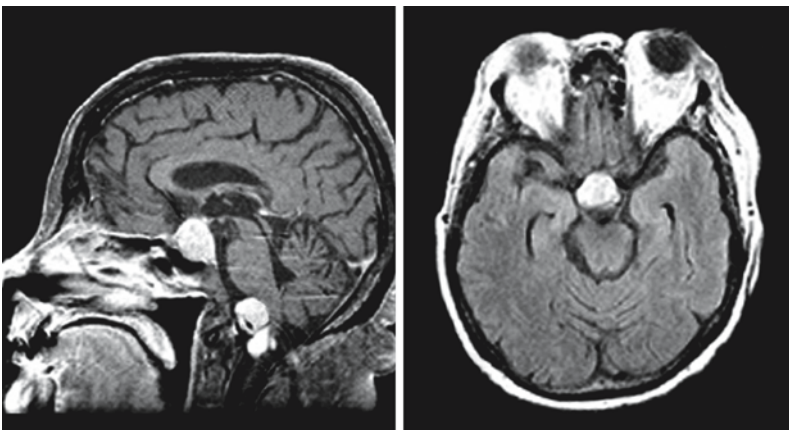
A 55-year-old woman with Erdheim–Chester disease, as confirmed at autopsy. The sagittal T₁-weighted image with contrast shows an intra- and suprasellar process, enlarging the sella turcica and reaching upward unto the optic chiasm. A second, extra-axial lesion is located anteriorly in the craniovertebral junction. Both lesions enhance homogeneously. The axial FLAIR image reveals the lesion with high signal intensity. From Thorns et al. (2003), with permission
